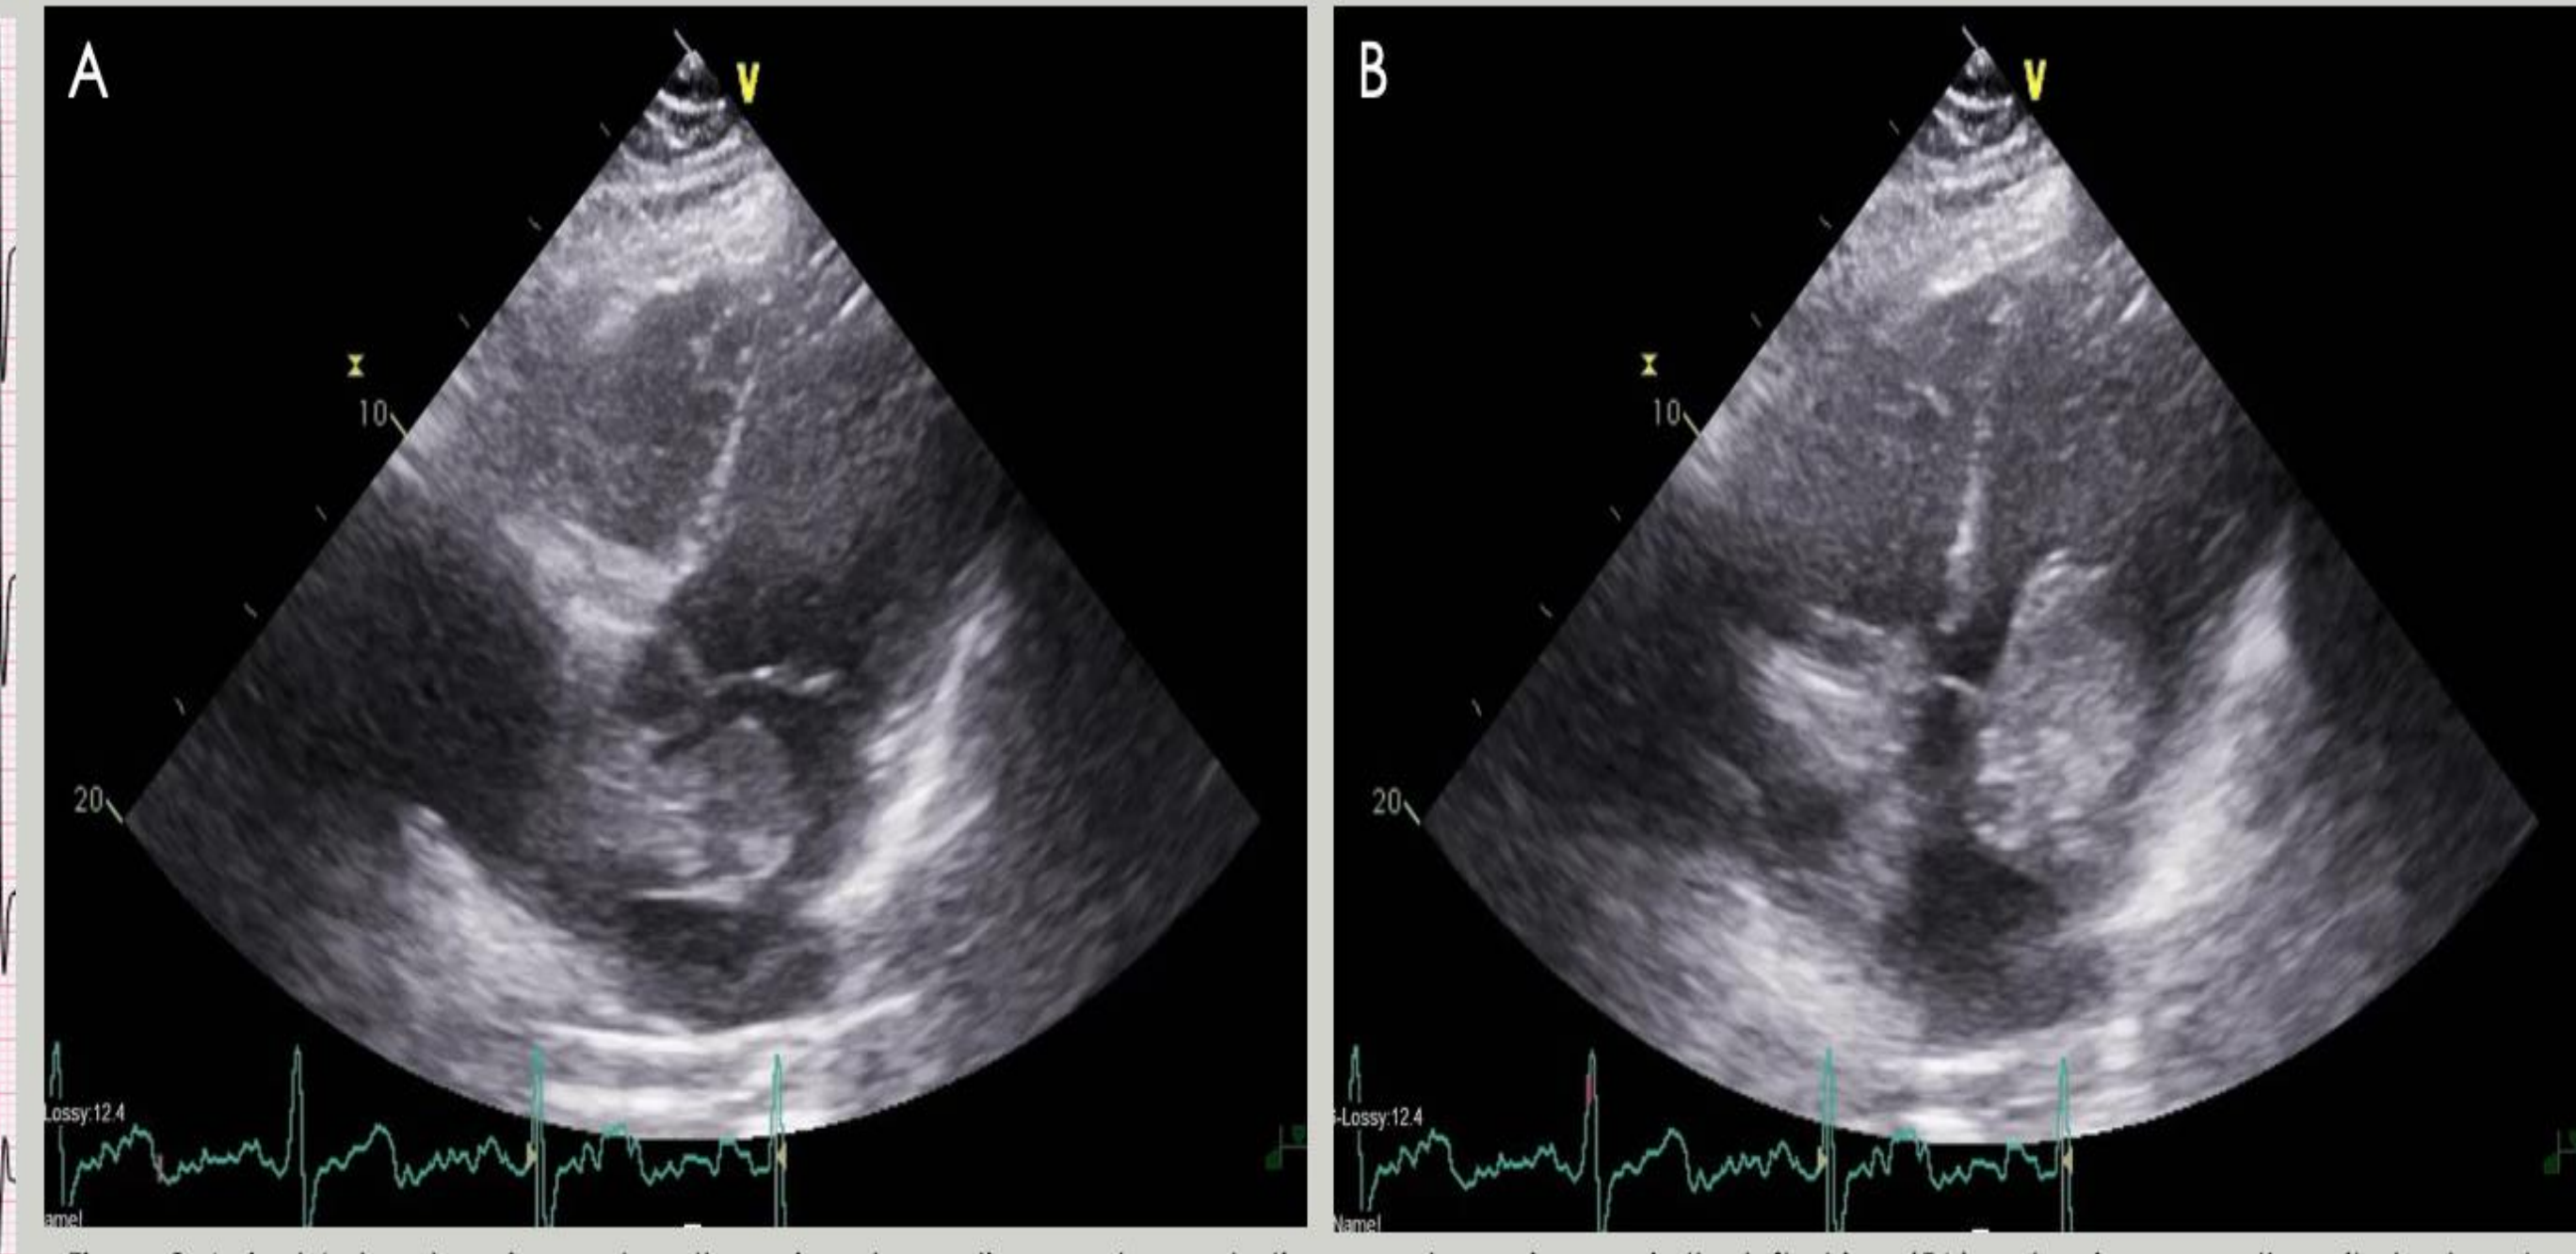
Apical 4 chamber view on transthoracic echocardiogram demonstrating an echogenic mass in the left atrium (5A) prolapsing across the mitral valve at end diastole (5B)
